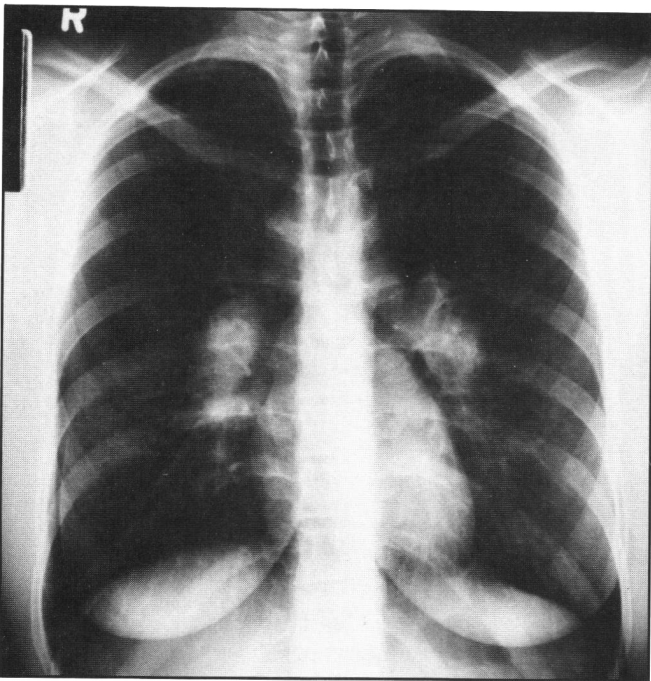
Chest x-ray showing hilar and paratracheal lymphadenopathy.
